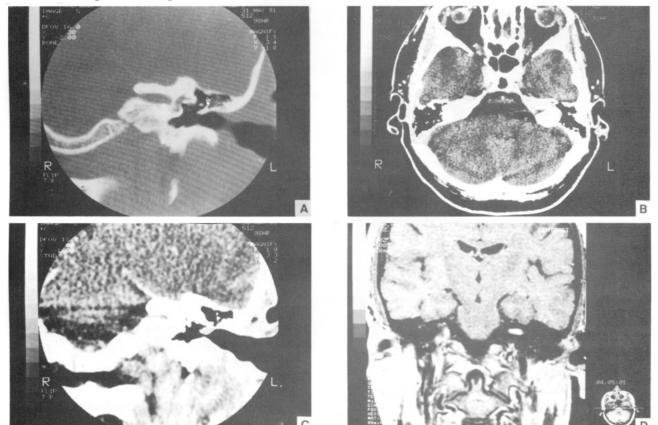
A-D: (Case 1) Coronal plane magnified bone review algorithm image of lett temporal bone with normal internal acoustic canal walls. Note that normal extension of the falciform crest is not seen (A). Axial standard resolution CT section from the level of the left internal acoustic canal showing intracanalicular contrast enhancement with normal cerebellopontine cistern (B). Magnified coronal standard resolution CT section of left temporal bone shows a contrast-enhanced soft tissue increase obliterating the intracanalicular CSF space (C). Coronal plane short TRTE spin echo MR image with Gd-DTPA injection reveals a hyperintense acoustic neuroma in the left internal auditory canal (D).
